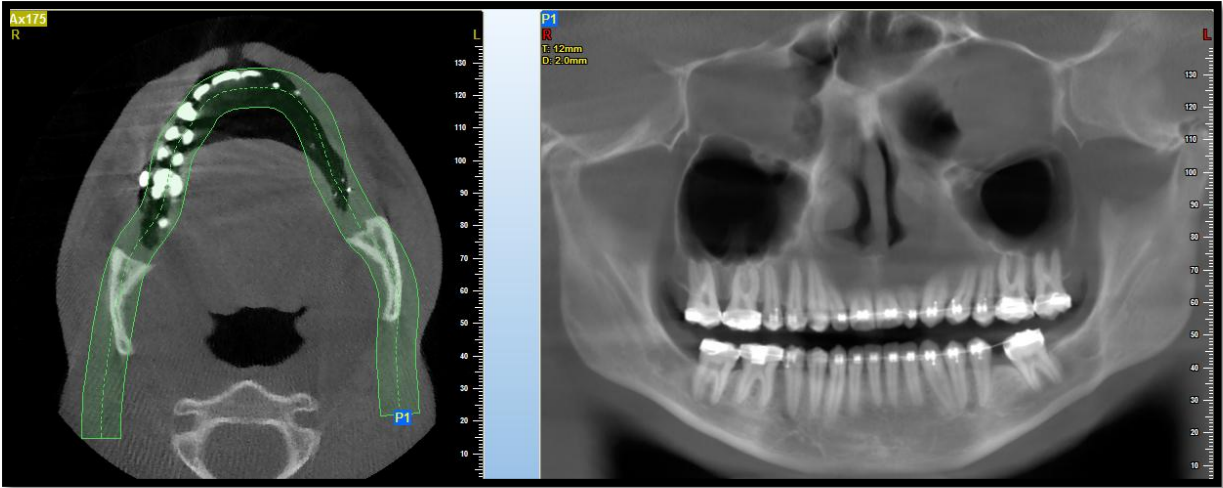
Orthopantomogram 12 mm in thickness
